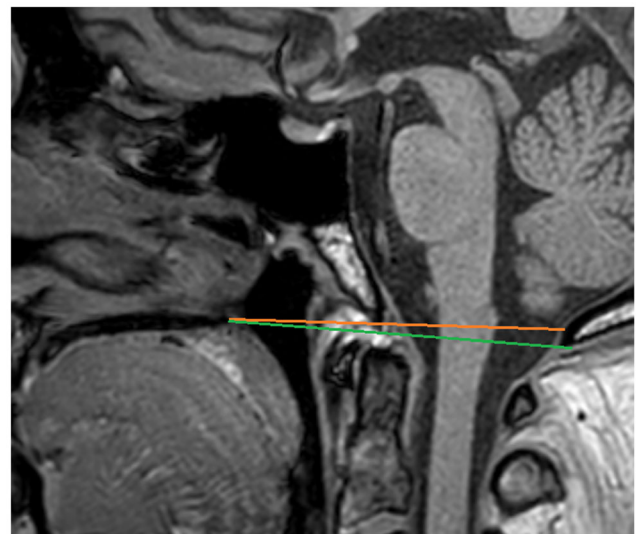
Normal craniocervical junction on a sagittal T1-weighted image. The Chamberlain line (*brown*) runs from the hard palate to the opisthion. The McGregor line (*green*) runs from the hard palate to the lowest point of occipital squama. The tip of the odontoid process typically lies below these lines in normal cases
